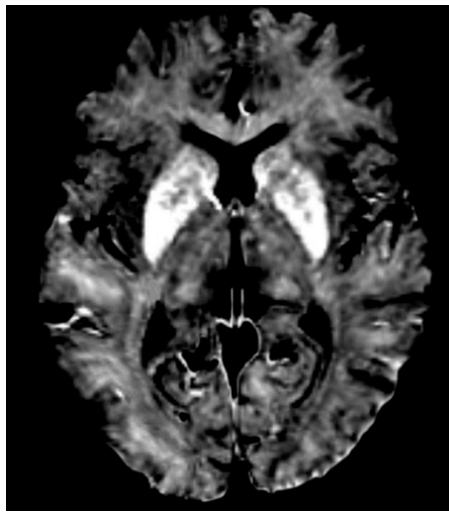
MRI image of iron concentration ($R2^*$) in the brain from study II; the brightest regions correspond to parts where iron accumulates.
